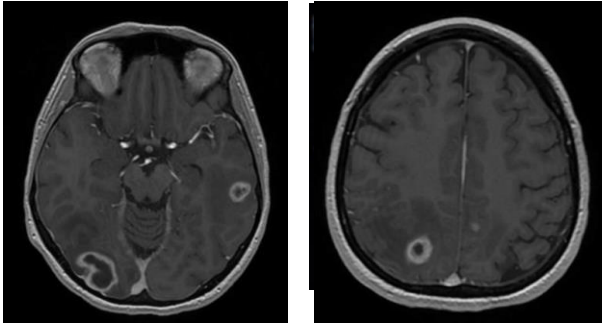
Expansive intracerebral processes, mostly supratentorial, one millimeter infratentorial, with an MRI appearance suggesting an infectious substrate - brain abscesses.
